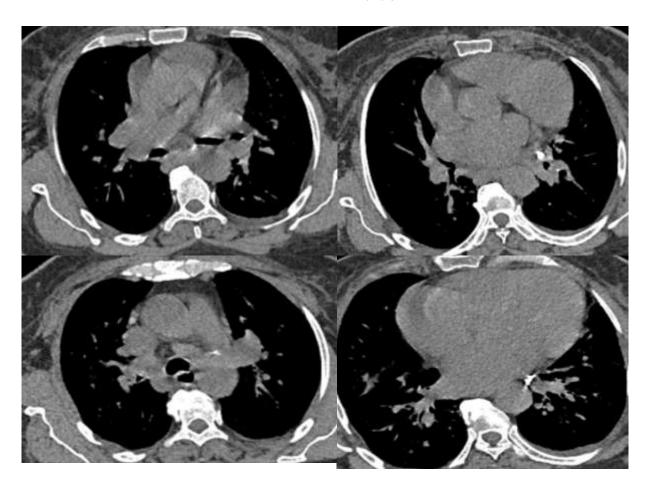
Multiple axial cuts of CT chest mediastinal window of female patient 55 years old showing Multiple mediastinal LNs as well as bilateral hilar calcified LNs more pronounced at the left side.
